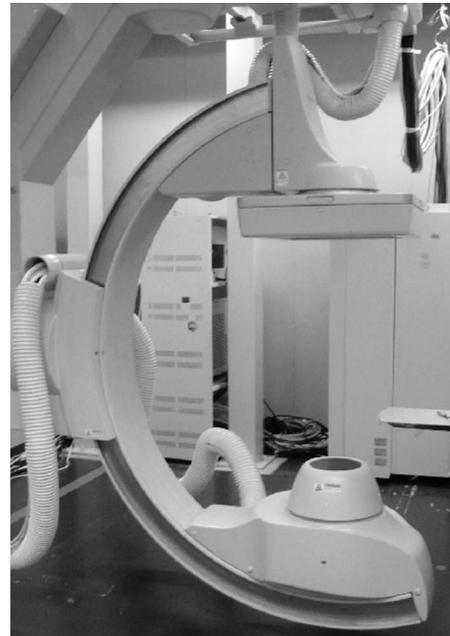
C-arm CBCT system, Shimadzu BRANSIST safire with a FPD of 17 in. size.
